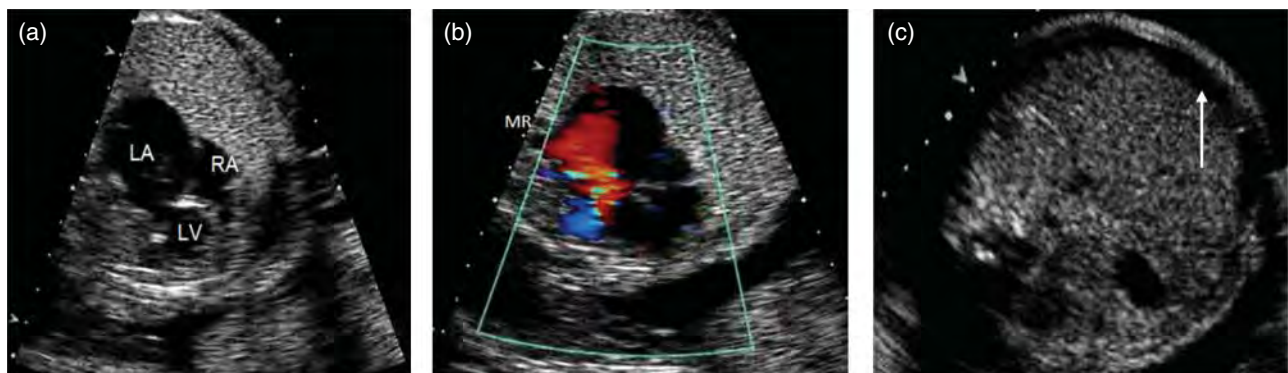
Echocardiographic imaging in a fetus with severe aortic valve stenosis resulting in hydrops fetalis. Unlike the previous case, at 30 weeks, severe mitral regurgitation (MR) was present. In the setting of outflow tract obstruction, the usual evolution is progressive ventricular hypoplasia. However, when significant atrioventricular valve insufficiency develops, the ventricle undergoes significant dilatation. (a) Four-chamber view shows severe left ventricle (LV) dilatation. There is severely decreased systolic function, and left atrium (LA) dilatation which compresses the right atrium (RA). (b) Severe mitral regurgitation. (c) Development of significant ascites and hydrops.
